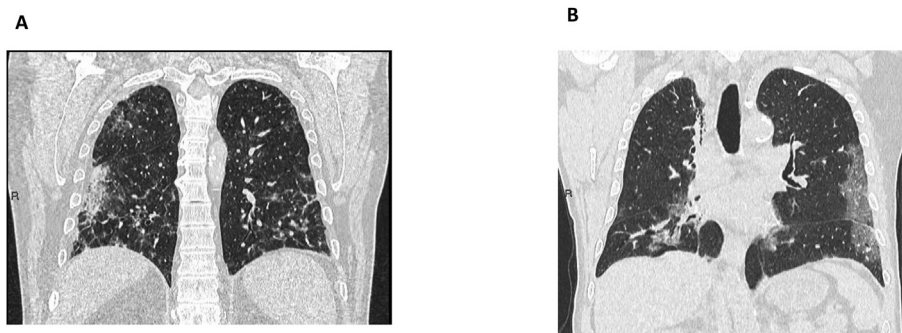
Volumetric high-resolution thoracic CT (HRCT) scans of a no-COVID-19 patients (A) and COVID-19 patient (B).
